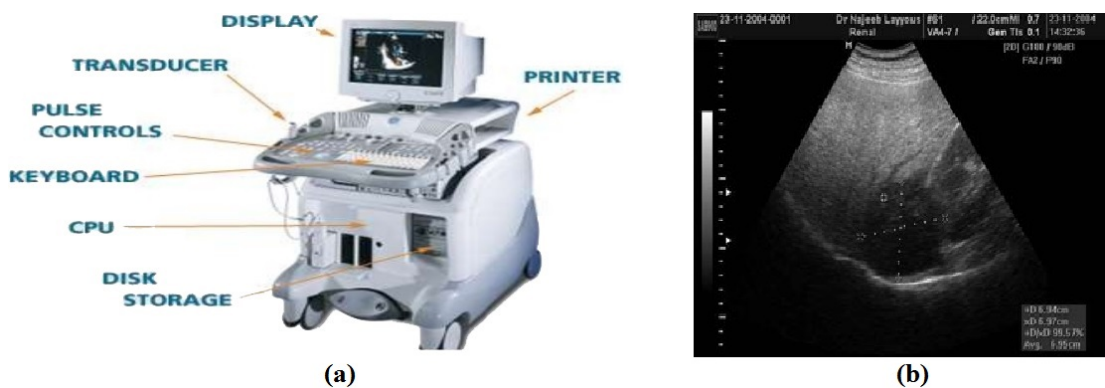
Ultrasound. (a) Ultrasound device. (b) Sample of ultrasound image.
